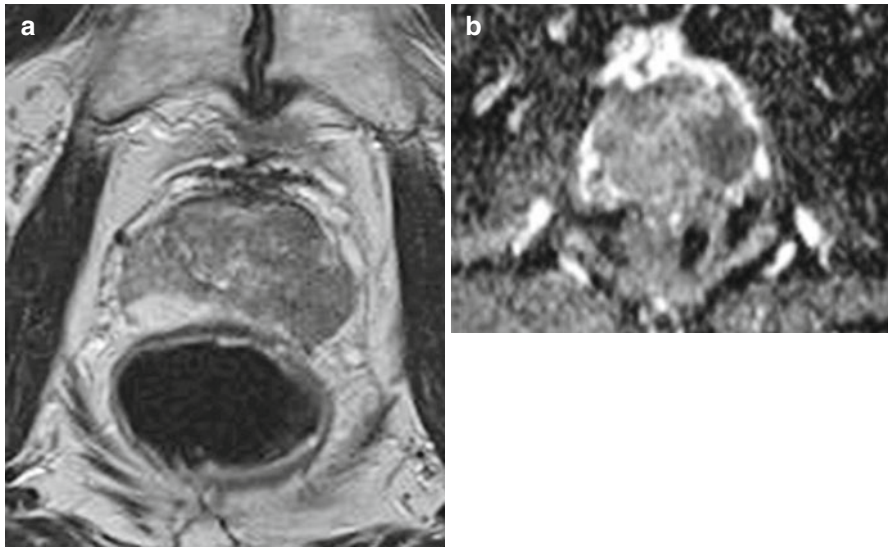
Left sided carcinoma on T2 MRI (a) and on DWI-MRI (b)
